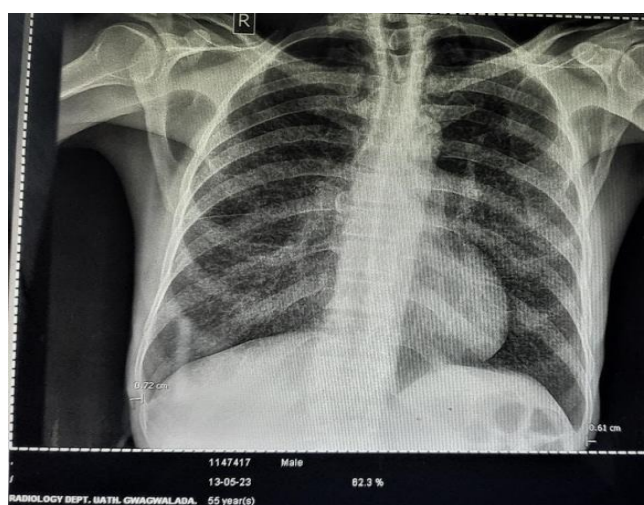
plain chest radiograph shows generalized diffuse miliary pattern with marked thinning of the lateral chest wall soft tissues consistent with wasting.
